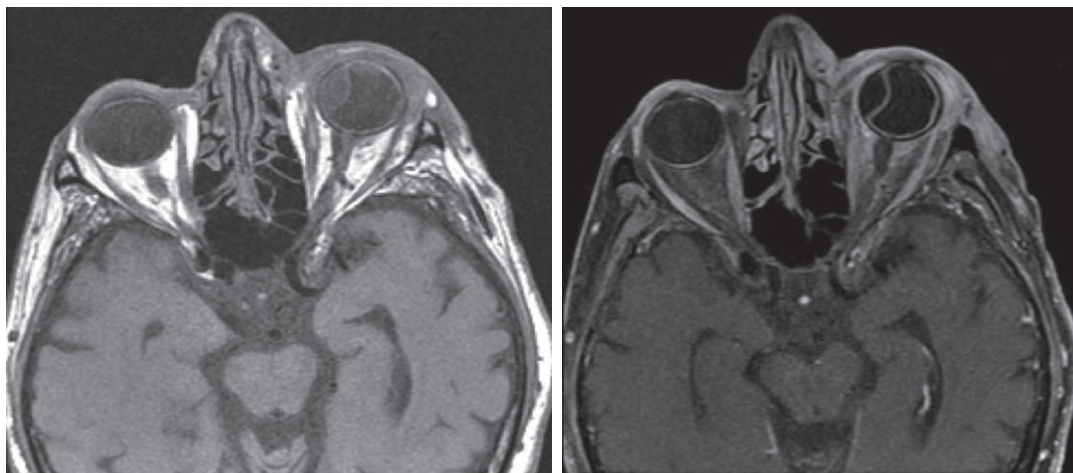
T1-weighted MRI shows extensive inflammation of the left preseptal and orbital tissues, in addition to a choroidal detachment.
